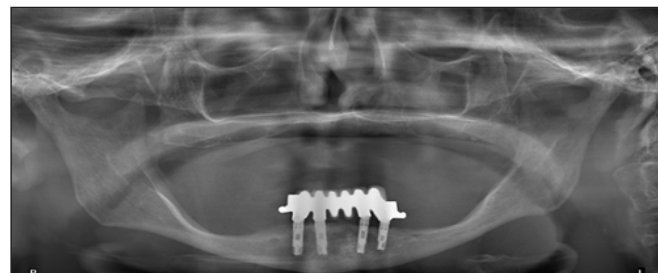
Panoramic radiograph. The panoramic view showing the severely atrophic (class VI) Maxilla, pre-surgical.
